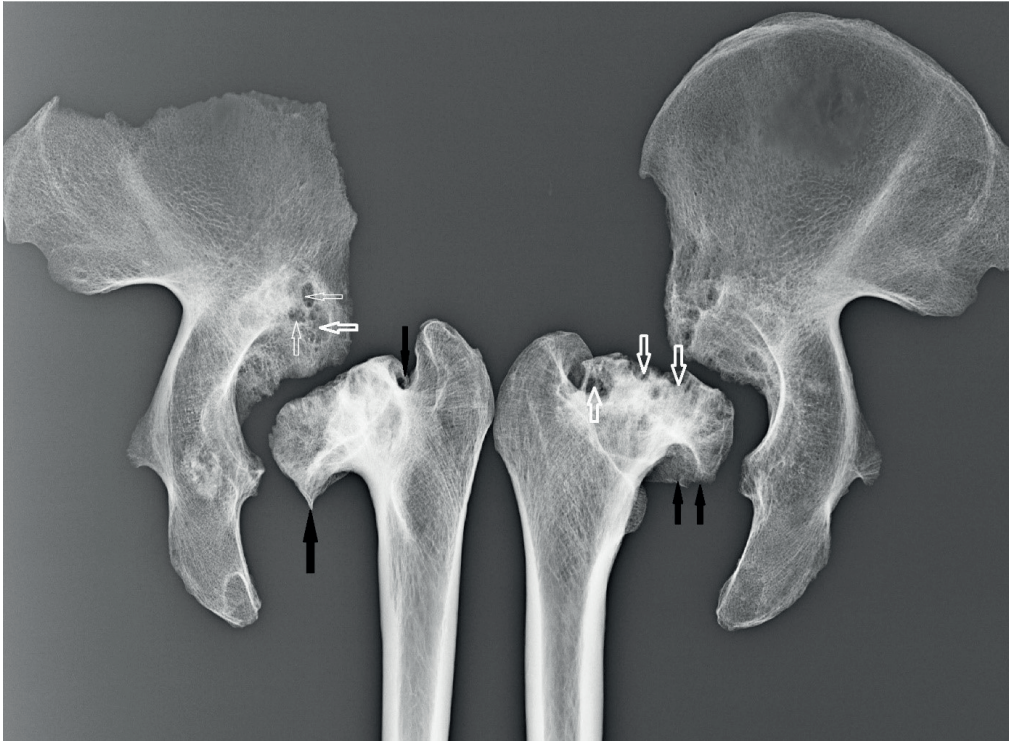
Radiographs the femurs (proximal end) and pelvic bones with observable necrosis (white arrows) and osteophytes (black arrows) (No. 317/13)
